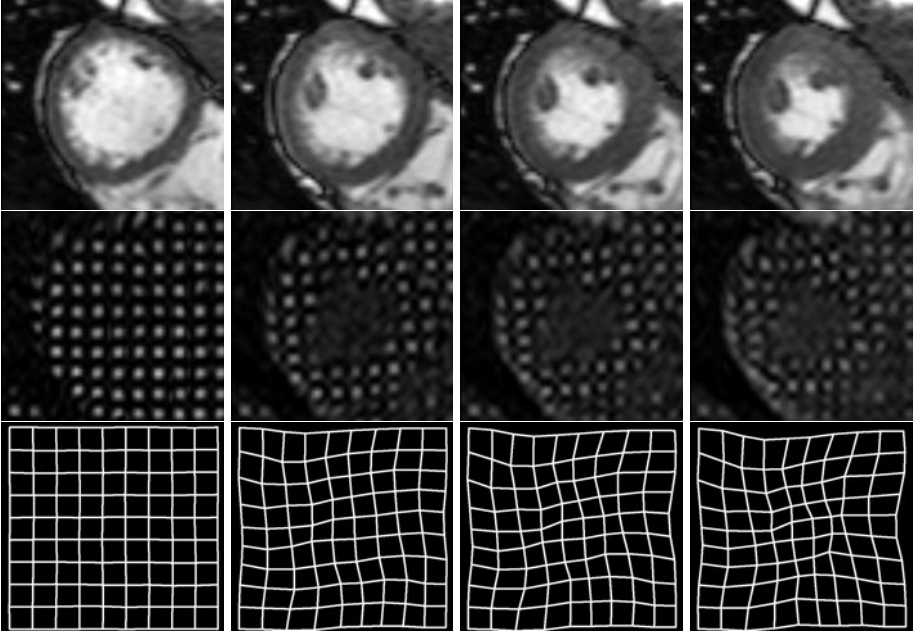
Untagged (top row), tagged (middle row) MR images and the extracted motion fields (bottom row) from one volunteer
